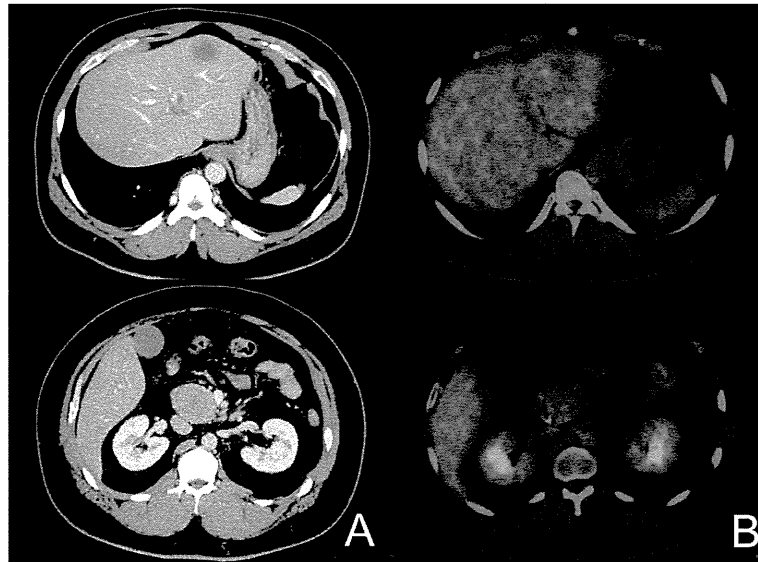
A: Enhanced computed tomography (CT) showing hypovascular tumors in the pancreas and liver. B: The pancreas and hepatic tumors showed low levels of standardized uptake value (SUV) for FDG (SUVmax=3.0) in fluorodeoxyglucose-positron emission tomography integrated with CT imaging (FDG-PET CT).
